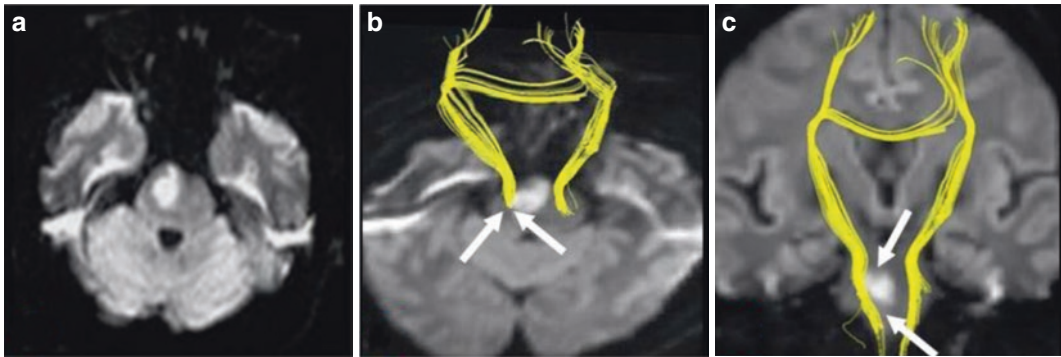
Right pontine infarction. A 59-year-old male patient who presented with left limb weakness and slurred speech for 2 d. The patient recovered after 3 months of routine medical treatment and rehabilitation training. Transverse DWI shows right pontine infarction (a).
